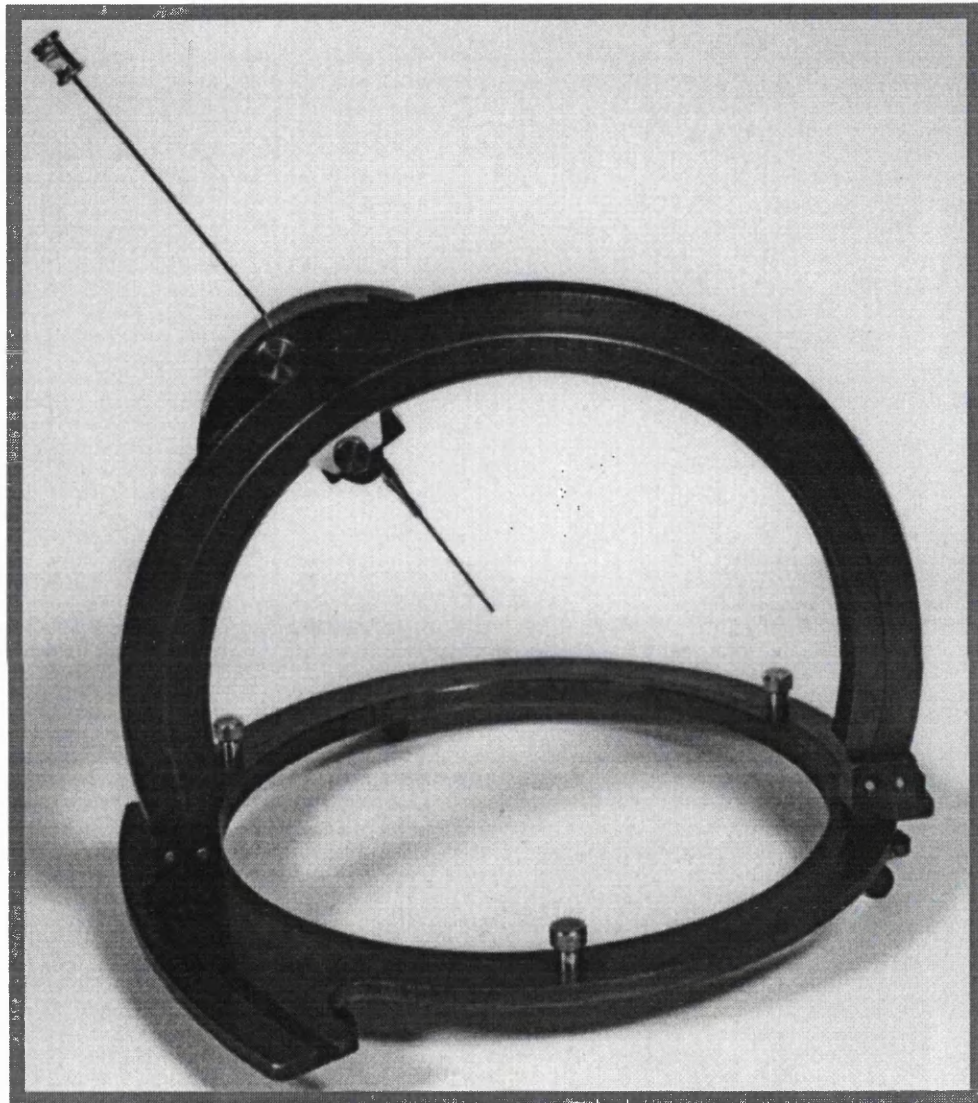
Photograph of the Brown-Roberts-Wells stereotactic frame. This system was the first to be designed specifically for CT-directed procedures and, although target-centred, the BRW achieved widespread popularity.
